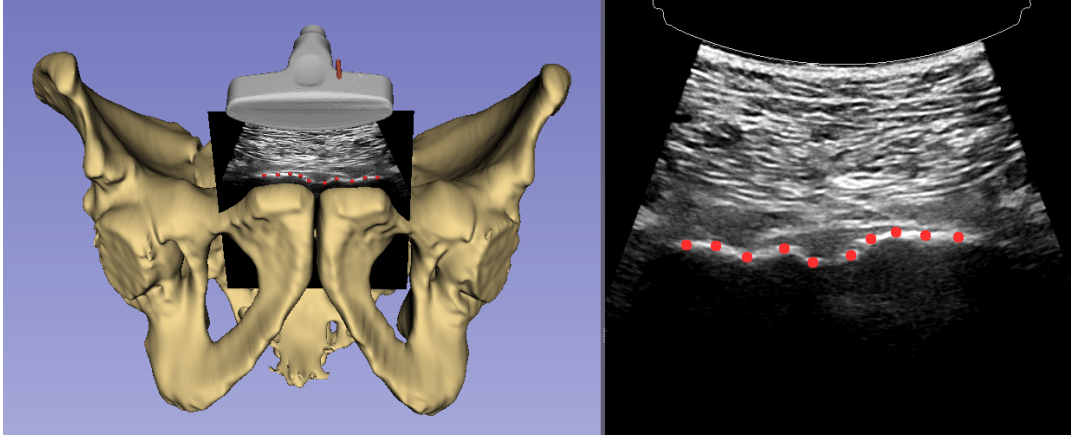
Post-operative landmark selection of the bone surface on US images. A recorded 2D ultrasound image of the pubic bone (right), ten landmarks (red dots) and their location relative to the initial transformed 3D bone model (left) are visualized.
